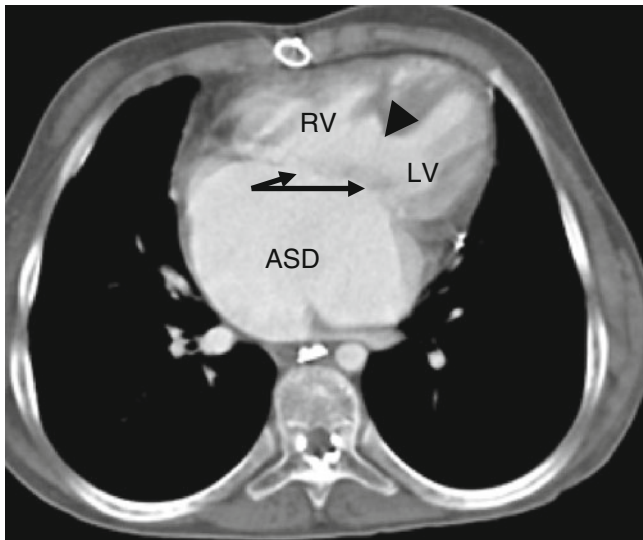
Type 3 VSD (synonyms: inlet, AV canal type, endocardial cushion defect). This axial computed tomography image shows the defect (*black arrowhead*) located in the inlet of the right ventricular septum. Also note the associated primium atrial septal defect (ASD) and single atrioventricular valve (atrioventricular canal morphology, *black arrows*) in this patient with trisomy 21 syndrome. *RV* right ventricle, *LV* left ventricle, *ASD* atrial septal defect
